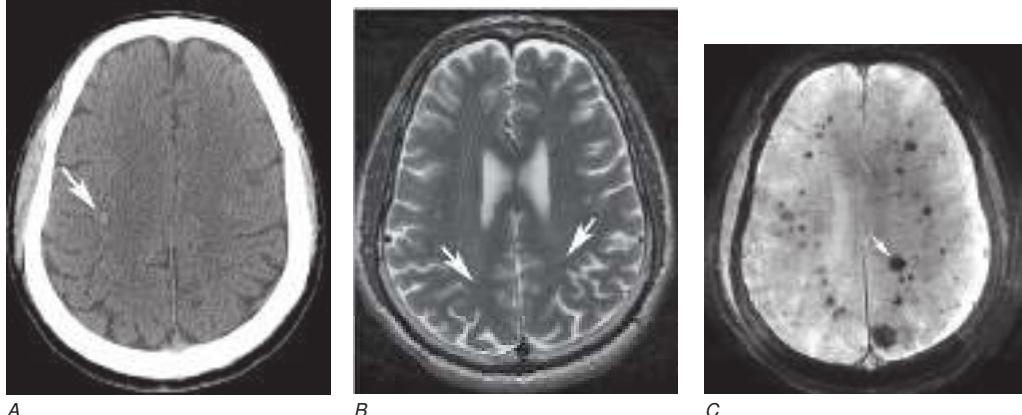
Susceptibility-weighted imaging in a patient with familial cavernous malformations. *A*, Noncontrast computed tomography scan shows one hyperdense lesion in the right hemisphere (arrow). *B*, T2-weighted fast-spin echo image shows subtle low-intensity lesions (arrows). *C*, Susceptibility-weighted image shows numerous low-intensity lesions consistent with hemosiderin-laden cavernous malformations (arrow).
